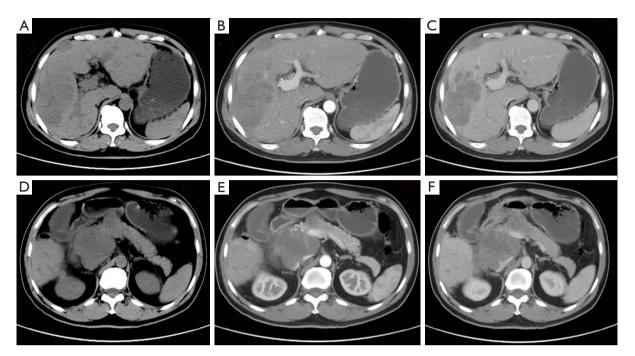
CT images before initiation of six courses of HAIC showed multiple well-circumscribed, heterogeneous, hypodense liver masses. (A) The largest was located in the right lobe of the liver and measured about 9.2 cm × 6.3 cm × 8.8 cm in diameter. Masses with significant contrast enhancement during the (B) arterial and (C) portal phases. A massive portal lymph nodes lesion appeared as (D) hypodense on unenhanced CT scanning. (E) heterogeneous arterial hyperenhancement and (F) washout in the portal phases after contrast. CT, computed tomography; HAIC, hepatic arterial infusion chemotherapy.
